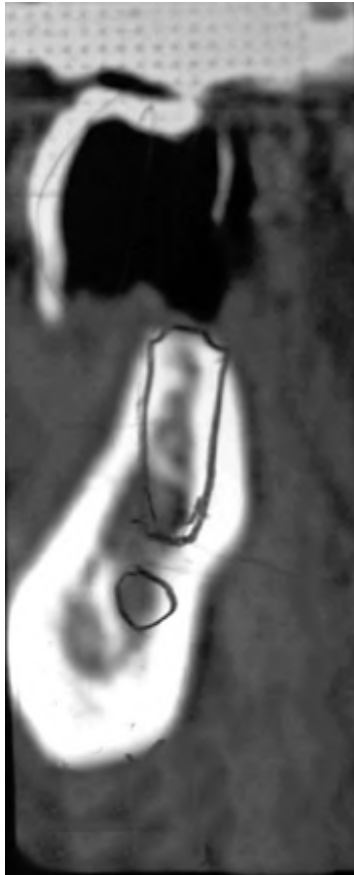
This particular lateral slice of the CT scan identified the precise location of the inferior alveolar canal and the midportion of the planned implant restoration. Tentatively, a 5×11.5 -mm implant was selected for this particular edentulous area. CT scans have the requisite accuracy for surgeons to feel confident that their osteotomy preparations and implant placement will not encroach on important anatomical structures.
